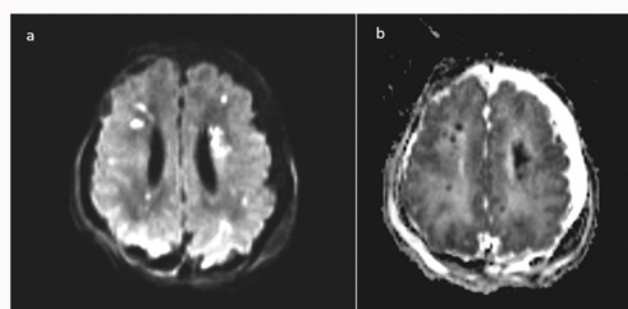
Axial MR images showing bilateral periventricular foci of increased signal intensity in Diffusion-Weighted Imaging (DWI, a) with decreased signal-intensity in the correlating ADC image (b), consistent with ischemic foci.
